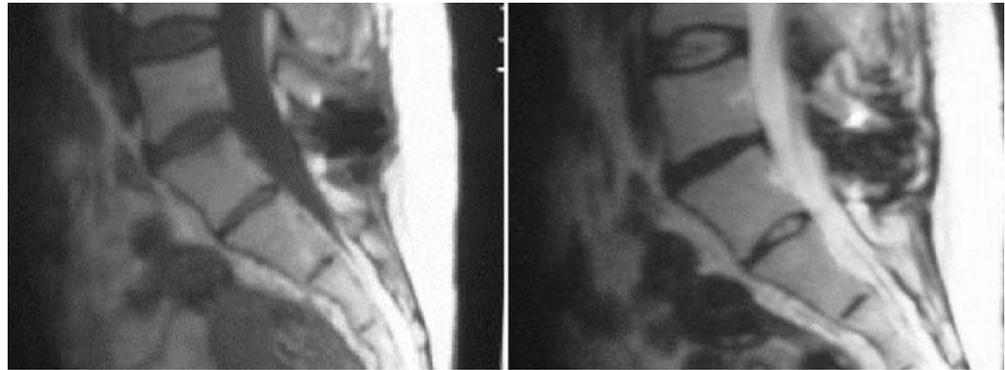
Magnetic resonance imaging aspect 11 years after non-rigid fixation
